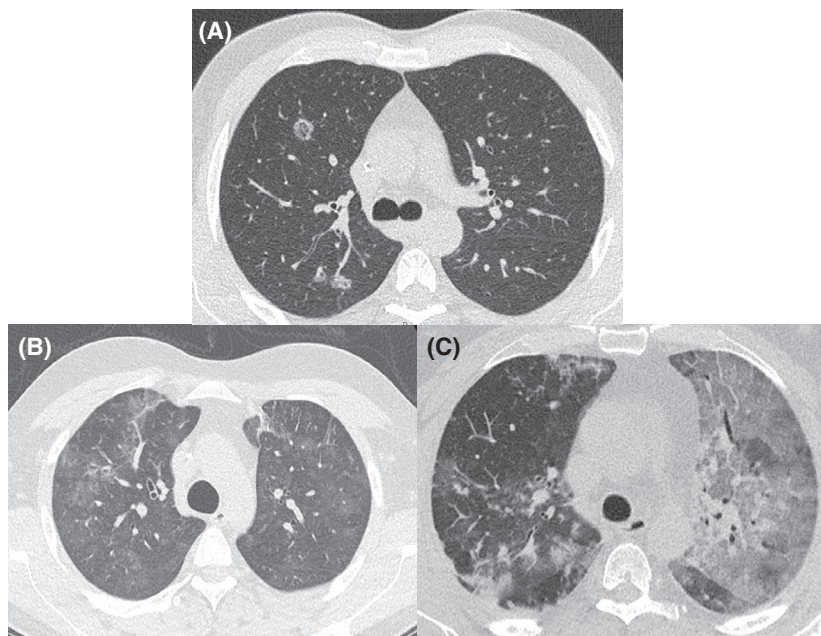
(A) Patient 1 – Axial view, high resolution computed tomography (HRCT) demonstrating three foci of parenchymal ground glass change surrounded by consolidation (the ‘reverse halo’ sign) in the right upper lobe. (B) Patient 2 – Axial view, chest HRCT demonstrating bilateral, multifocal ground glass change. (C) Patient 3 – Axial view, HRCT demonstrating widespread ground glass change most pronounced in the left upper lobe, predominantly subpleural and peribronchovascular consolidation and some interlobular septal thickening.
